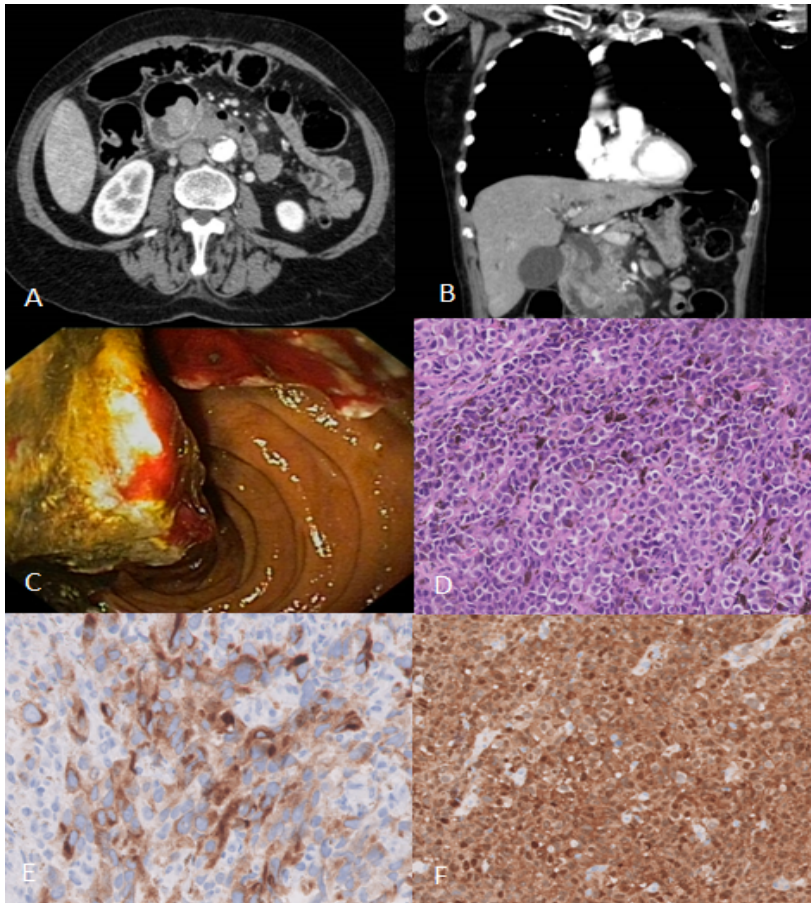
Radiological study. A and B. Abdomino-pelvic CT scan on the axial & coronal plane revealing a bilobulated duodenal lesion that, given its location, might represent a growth at the head of the pancreas or ampulla of Vater. Endoscopy. C. Ulcerated lesion at the duodenal ampulla. Pathology. D. E and F. Large polygonal cells with off-center nucleus, prominent nucleolus, and cytoplasm with melanocytic pigment and MELAN-A, S100 positivity.
